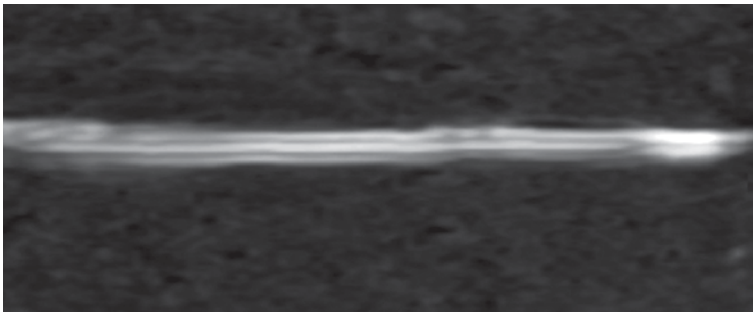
Sonographic anatomy of a normal trilaminar hair tract of the scalp
